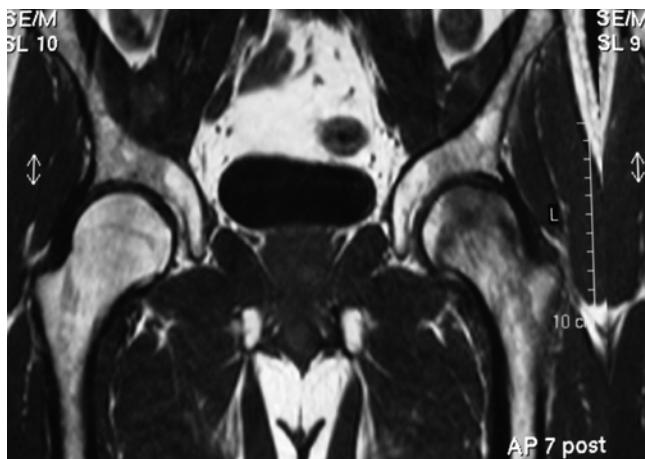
MRI findings (T1 sequence) of bone marrow edema syndrome showing dark, hypointense signal in left femoral head and neck
